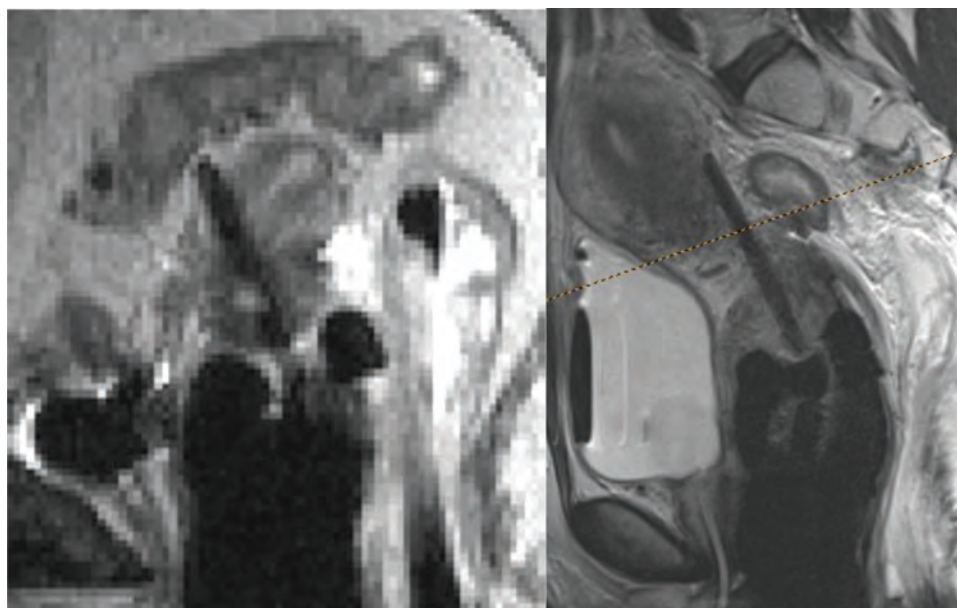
Examples of sagittal MRI with uterine tandem perforation. (Left) Patient with a retroflected small uterus, a large residual GTV, and an anterior perforation. (Right) Patient with large and hard residual GTV, no visible cervical os, a false posterior uterine pathway, and a posterior perforation.
